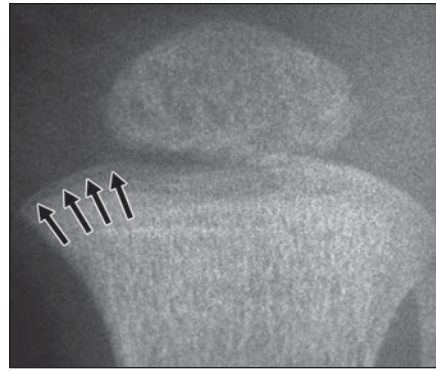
Left leg was swollen at birth in 6-day-old girl born healthy and at term but radiograph on day 2 was normal. Misclassified classic metaphyseal lesion from birth trauma literature. Arrow was reported to highlight neonatal “bucket-handle” fracture of distal femur after cesarean delivery; however, ringlike structure is inconsistent with planar nature of classic metaphyseal lesion and more likely represents displaced perichondrial ring secondary to epiphyseal slippage. (Reprinted with permission from [21])
